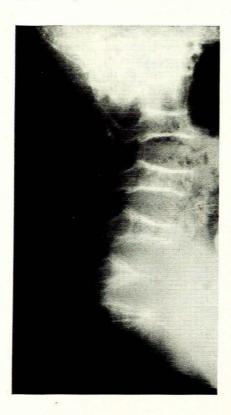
X-ray film of spine showing sclerosis of superior and inferior margins of the vertebral bodies with radiolucency of the bone and marked widening of the intervertebral disc.
